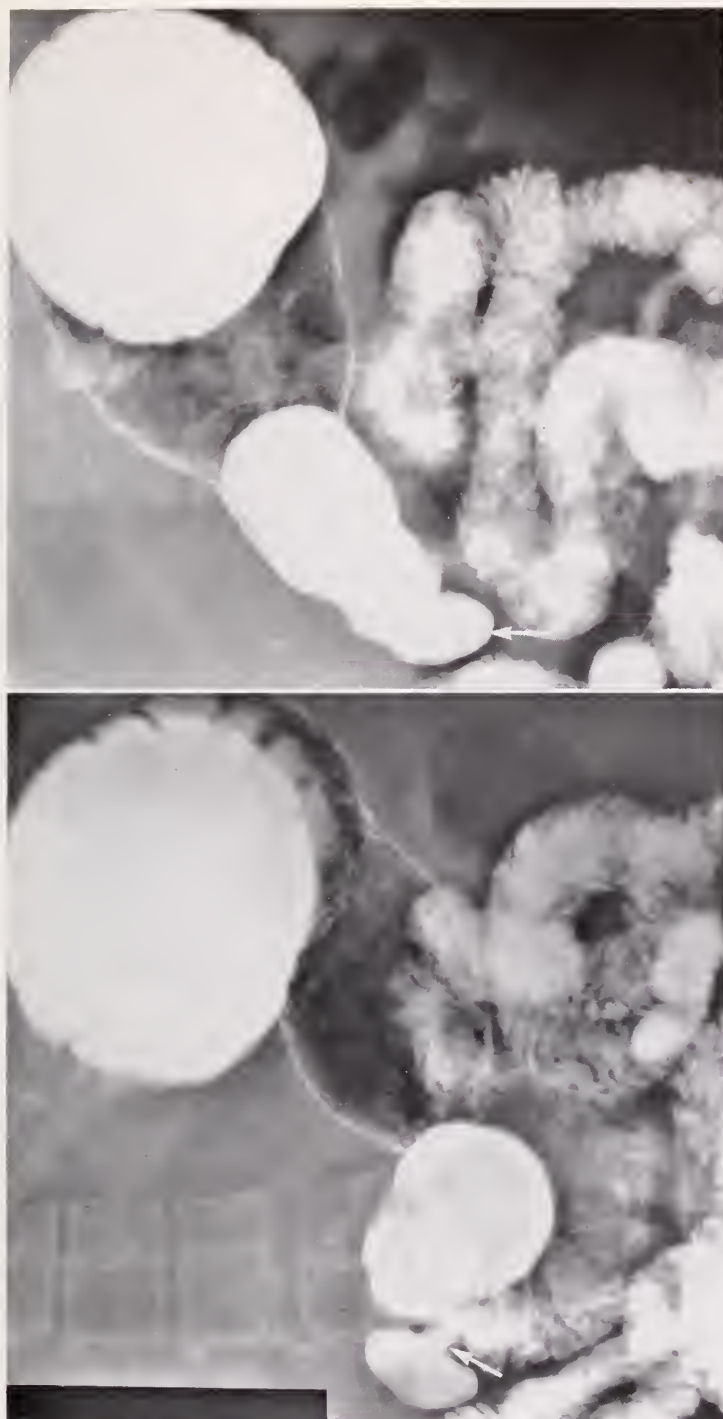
Right anterior oblique roentgenogram during a barium meal examination reveals a 2 x 3.5 cm diverticulum with a narrow neck (arrow) arising from the lesser curvature aspect of the post apical region of the duodenum. The bulb is not deformed. The folds of the second portion of the duodenum are normal.
